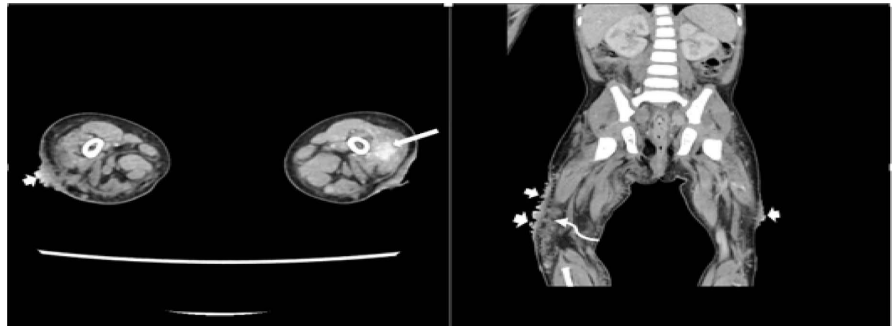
Axial CT and Coronal reformatted CT of the trunk and both thighs showing lipomatous infiltration of the subcutaneous fat of the right thigh with similar venous collaterals within it (wiggly arrow). An intensely enhancing left quadriceps muscle lesion concerning for a vascular malformation (long arrow) is seen. Epidermal overgrowth of the skin in the lateral aspects of both distal thighs—epidermal naevi (short arrows).
